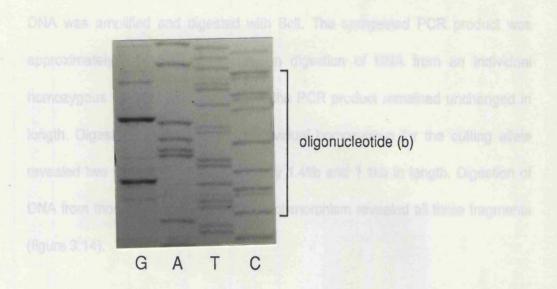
Auto radiograph of direct sequencing gel of 2.8 kb insert using the forward primer and showing the sequence of oligonucleotide (b) used for PCR amplification of the Bcl I polymorphism containing fragment
